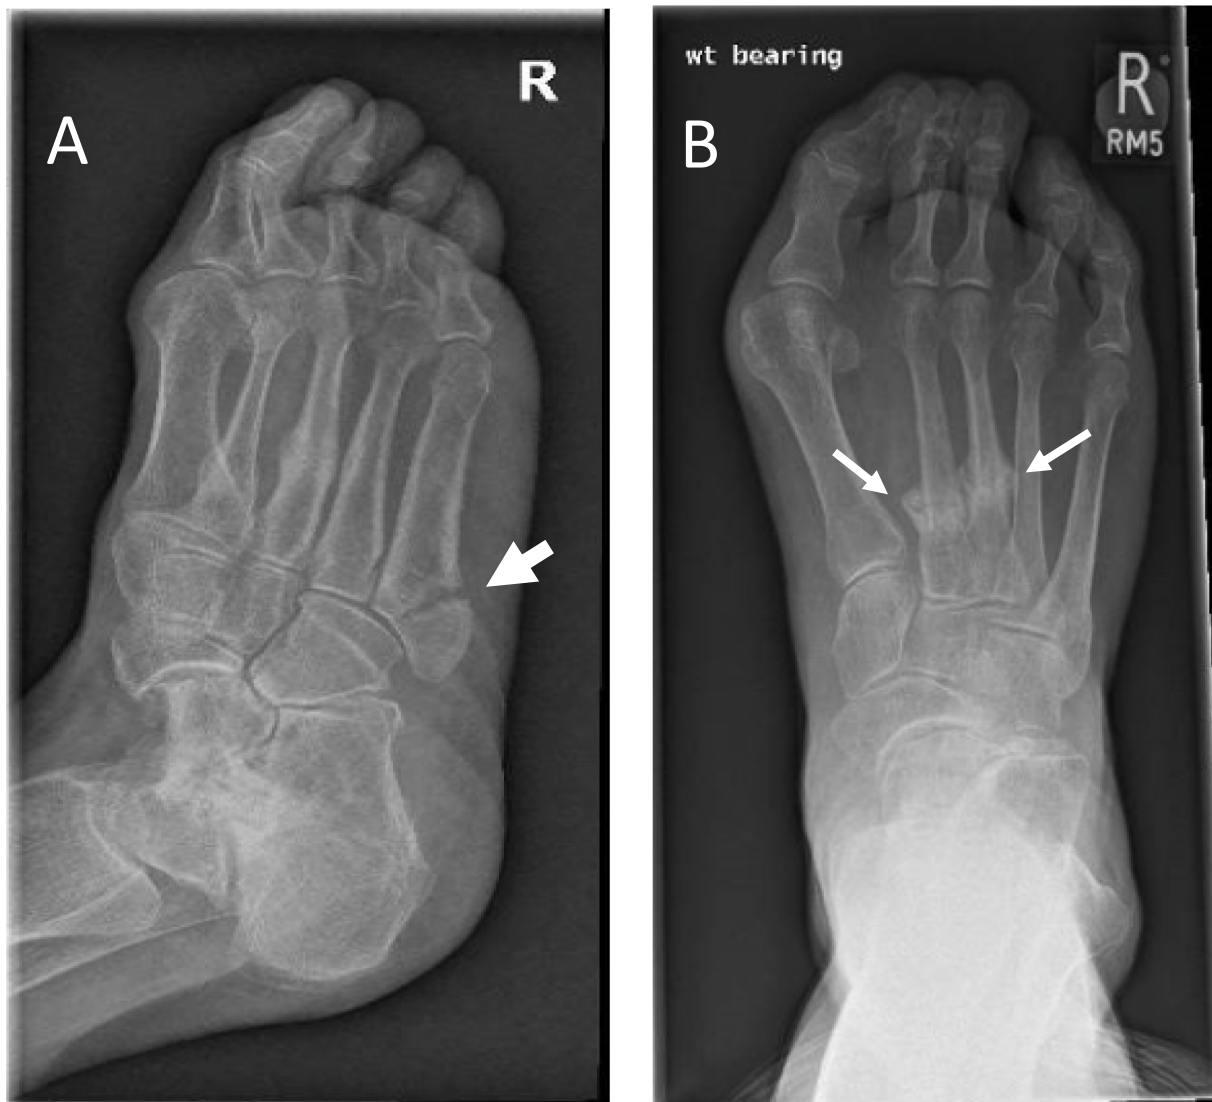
Case 1. X-rays of right foot showing (A) displaced fracture (arrow) at base of fifth metatarsal and (B) fractures with callus formation (two arrows) in shafts of second and third metatarsals.
